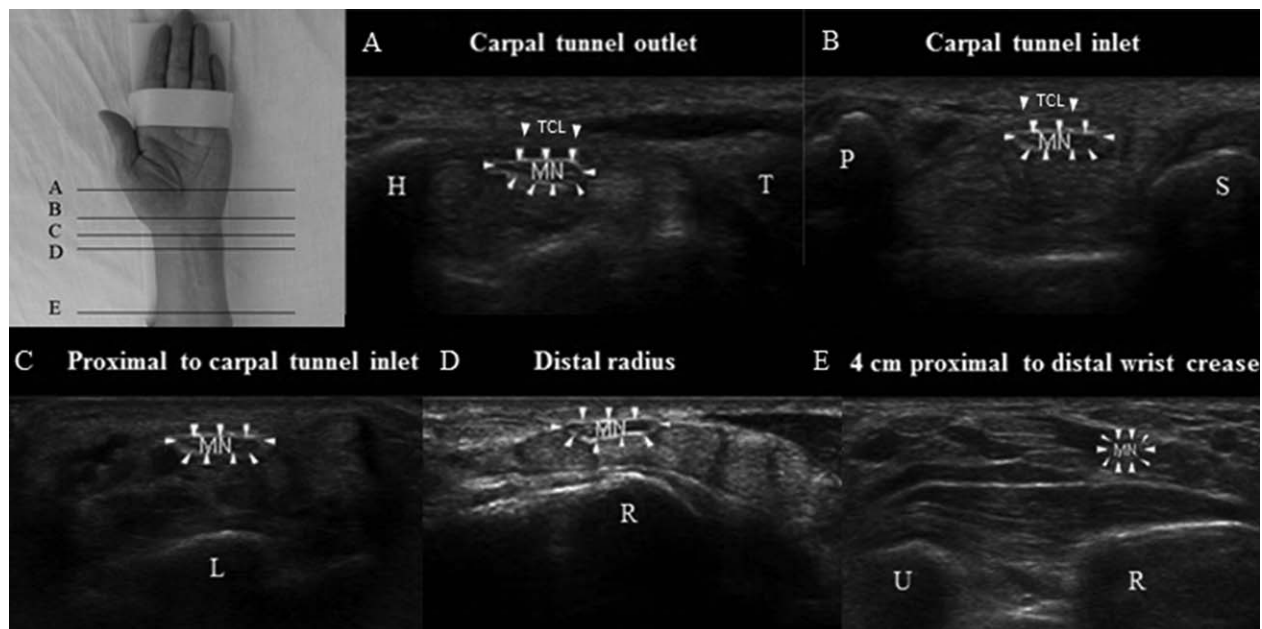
Locations for measurements of the 5 levels of the wrist. The ultrasound transducer was placed transversely at the 5 levels of the wrist: carpal tunnel outlet (A), carpal tunnel inlet (B), proximal to carpal tunnel inlet (C), distal radius (D), and 4 cm proximal to distal wrist crease (E). MN, median nerve; TCL, transverse carpal ligament. Bony landmarks are H, hamate; L, lunate; P, pisiform; R, radius; S, scaphoid; T, trapezium; U, ulnar.
